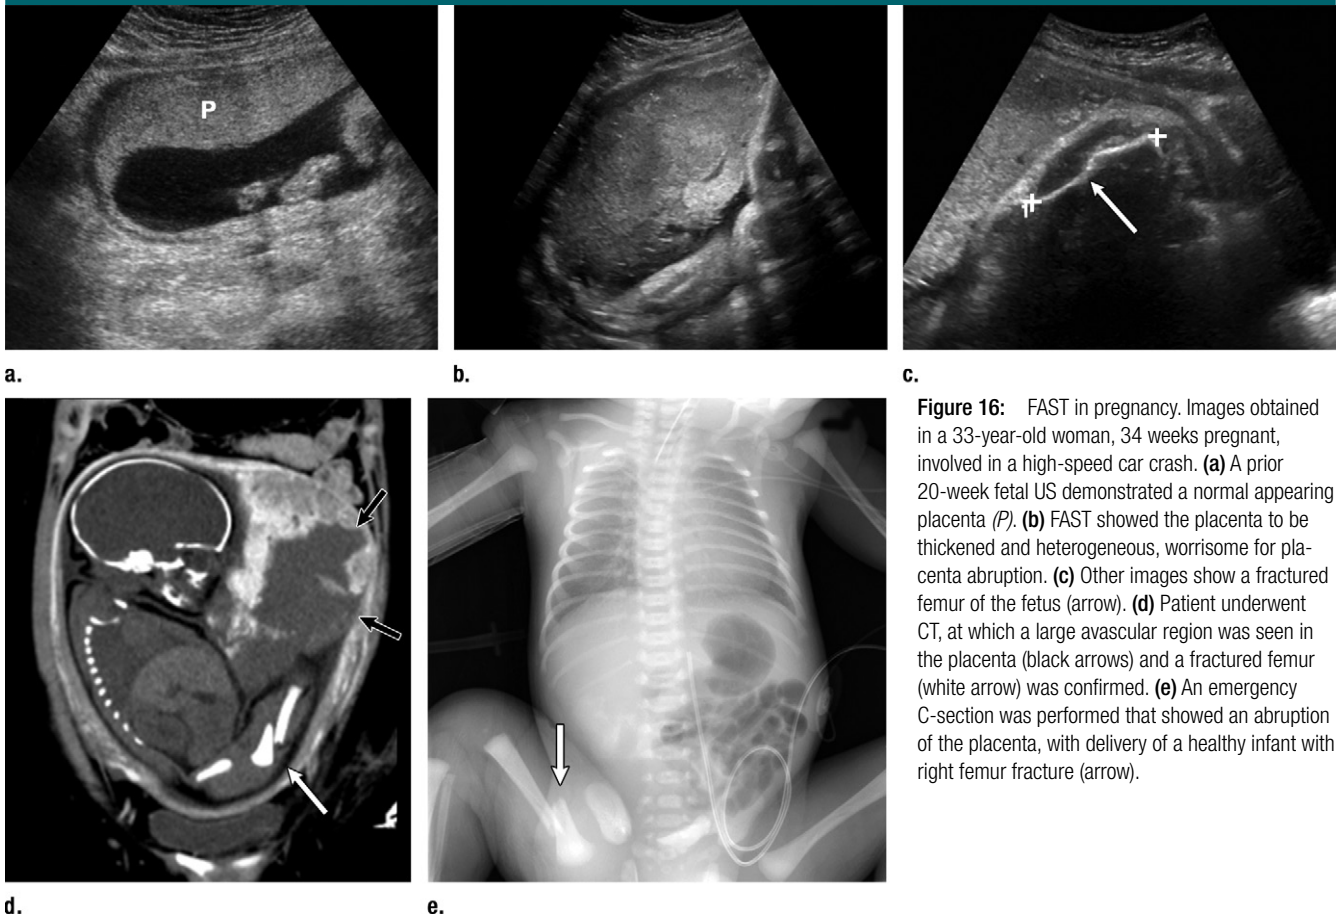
FAST in pregnancy. Images obtained in a 33-year-old woman, 34 weeks pregnant, involved in a high-speed car crash. (a) A prior 20-week fetal US demonstrated a normal appearing placenta (*P*). (b) FAST showed the placenta to be thickened and heterogeneous, worrisome for placenta abruption. (c) Other images show a fractured femur of the fetus (arrow). (d) Patient underwent CT, at which a large avascular region was seen in the placenta (black arrows) and a fractured femur (white arrow) was confirmed. (e) An emergency C-section was performed that showed an abruption of the placenta, with delivery of a healthy infant with right femur fracture (arrow).
